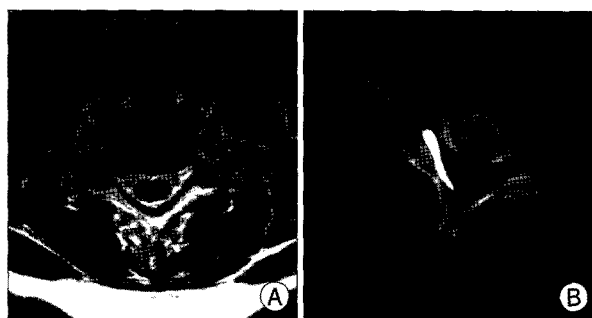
A 51-year-old female had been suffering from severe right arm pain for 1 month. The axial T2-weighted magnetic resonance image (A) shows disc herniation at the C6-7 level on the right side. A bone set image from CT fluoroscopy at the C6-7 level (B) shows a well-placed needle and injected contrast media inside the foramen and posterolateral epidural space. The needle is kept safely away from the carotid artery, internal jugular vein, and vertebral artery. The head is turned to the contralateral side.
